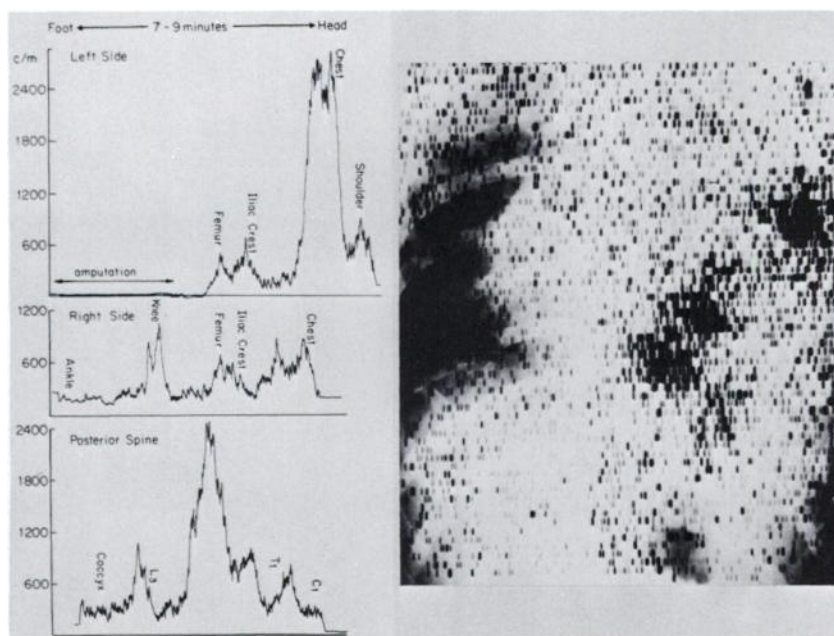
Left: linear axis profile showing prominent ^{85}Sr concentration localized to left chest. Right: rectilinear scan of chest superimposed on x-ray by use of coincidence markers. There is inhomogeneous uptake of ^{85}Sr in areas corresponding to calcified lung lesions.
